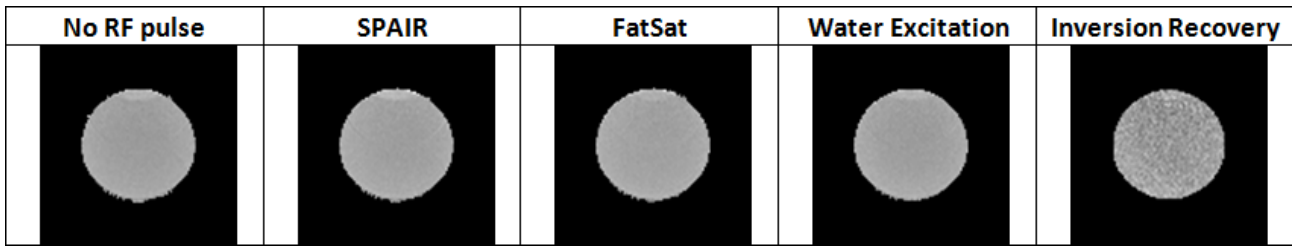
Five ADC maps from the same DWI sequence apart for the fat saturation technique. It is apparent, even at glance, the discrepancy in the IR ADC map.
